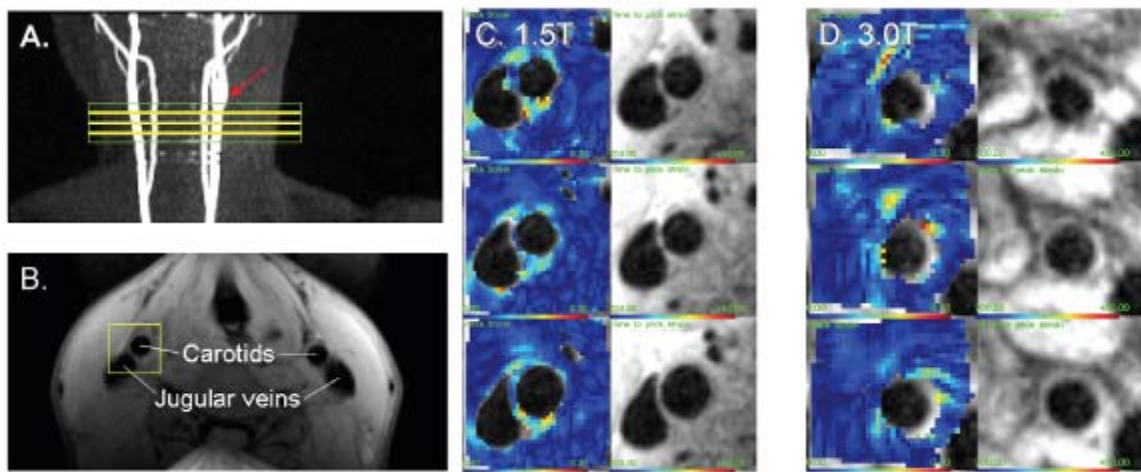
DENSE MRI. A) Slice locations (dotted lines) and shim volume (rectangle) of the DENSE and CINE MRI are indicated on maximum intensity projection images of 2D TOF MRI. Arrow indicates the carotid bifurcation used as a landmark. B) Raw DENSE phase image acquired at 1.5T. The rectangular volume indicates the area that is postprocessed using the DENSEview software. C) Three slices of the DENSE MRI acquired at 1.5T starting at the top from the inferior portion of the common carotid to just below the bifurcation. D) Three slices of the DENSE MRI acquired at 3.0T in the same order.
